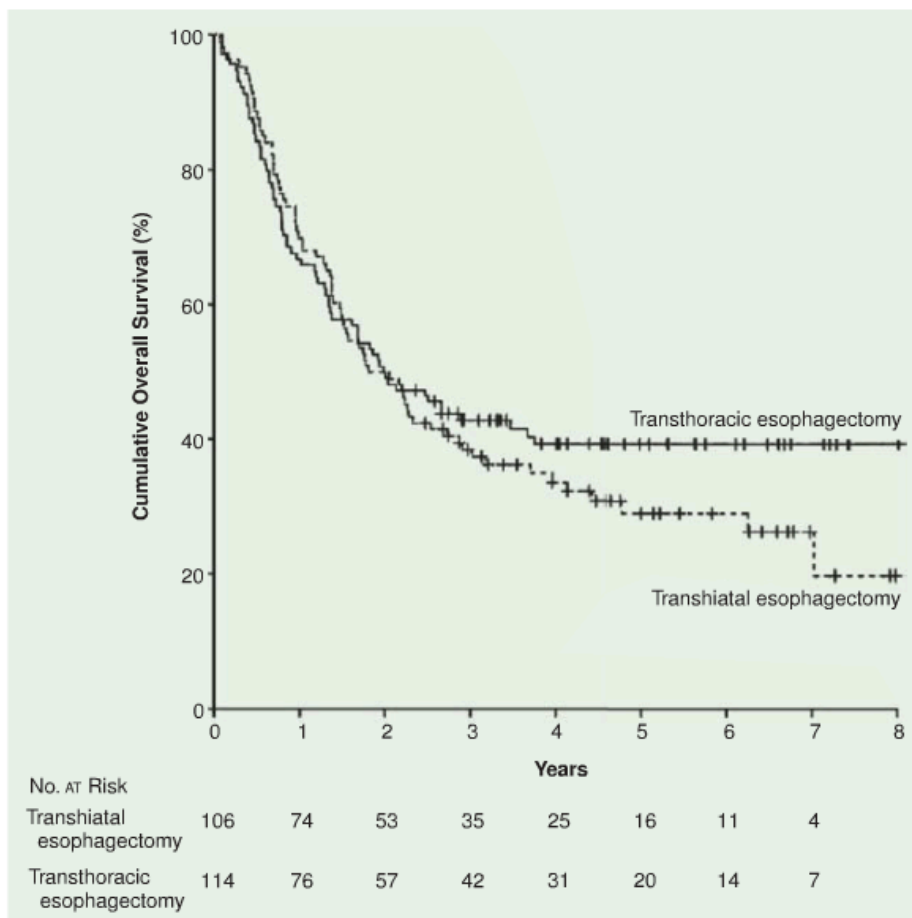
Overall survival among patients randomly assigned to transhiatal esophagectomy or transthoracic esophagectomy with extended en bloc lymphadenectomy. (Hulscher)
